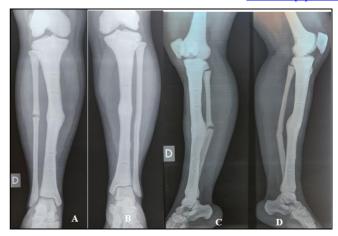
A + B: AP X-ray view showing a 5° valgus on the right tibia and normal axis on the left tibia. D+C: lateral X-ray view showing 14° hypercorrection flexum on the right tibia and normal axis on the left tibia
